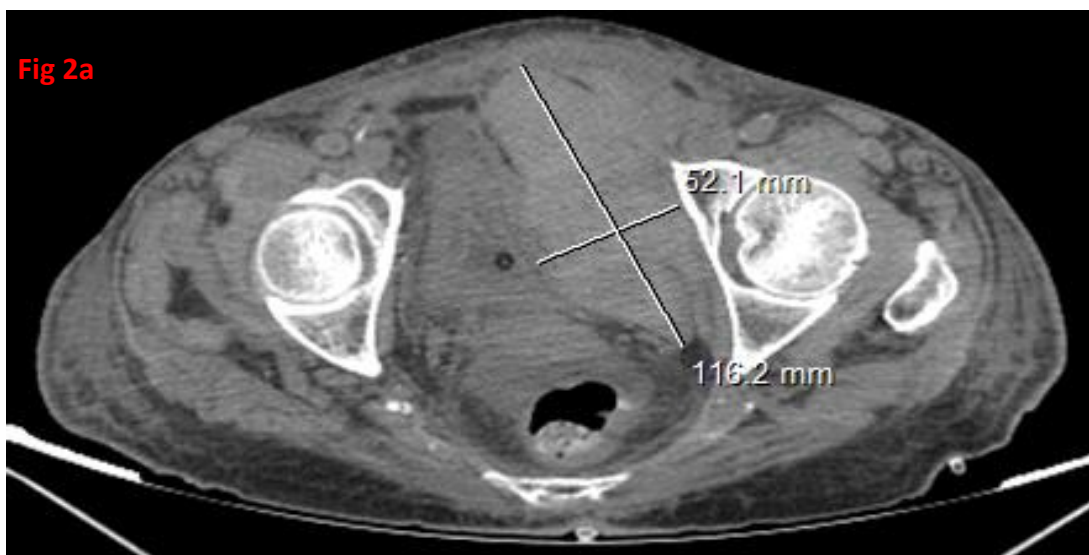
Abdomin-pelvic CT scan: cross section view: hematoma of the left rectus abdominis muscle measuring 116 x 52 mm. extending to a height of 140mm
